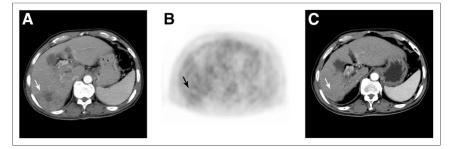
Pretreatment enhanced CT scan (A), PET scan (B), and 18 mo posttreatment enhanced CT scan (C) of patient with moderately differentiated HCC (arrow). Visual PET, T_{SUVmax} , T_{SUVmax} , T_{SUVmax} , and $CT/^{18}$ F-FDG PET score were negative, 2.5, 1.04, and 4, respectively. Patient underwent SABR of 33 Gy in 5 fractions. Tumor was well controlled during follow-up.
